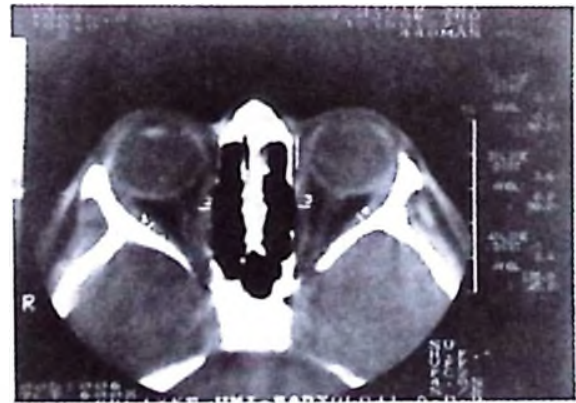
Orbital CT was normal after twenty days.
